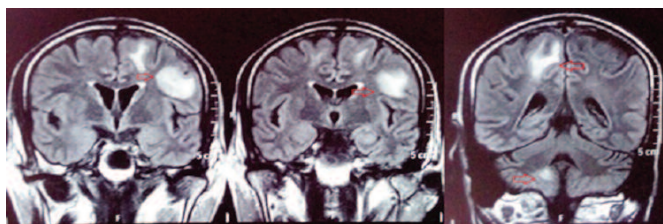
Magnetic resonance imaging Brain T2 weighted FLAIR (Fluid attenuated inversion recovery) sequence coronal sections showing hyperdense lesions (red arrows) in bilateral fronto-parietal and right cerebellar lesions with perilesional edema
